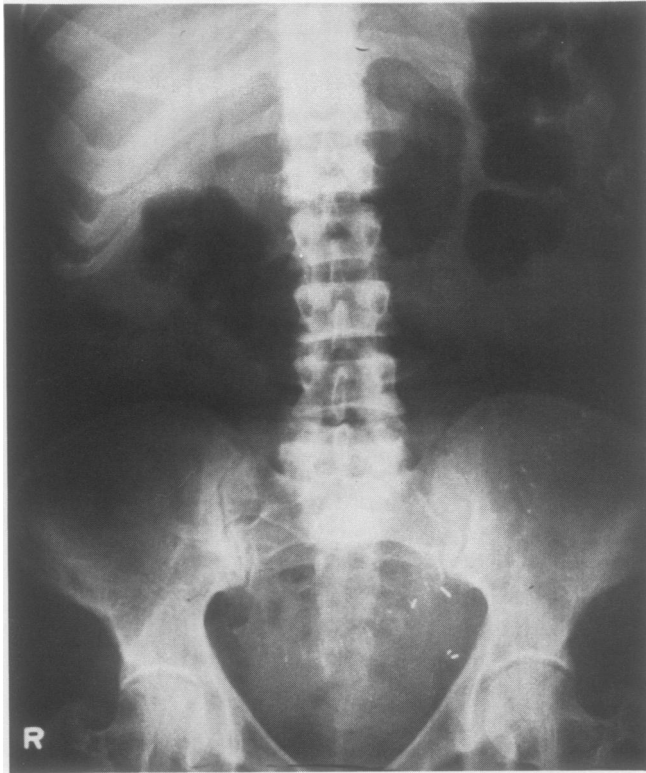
Abdominal roentgenogram showing marked reduction in cecal diameter following successful colonoscopic decompression.
